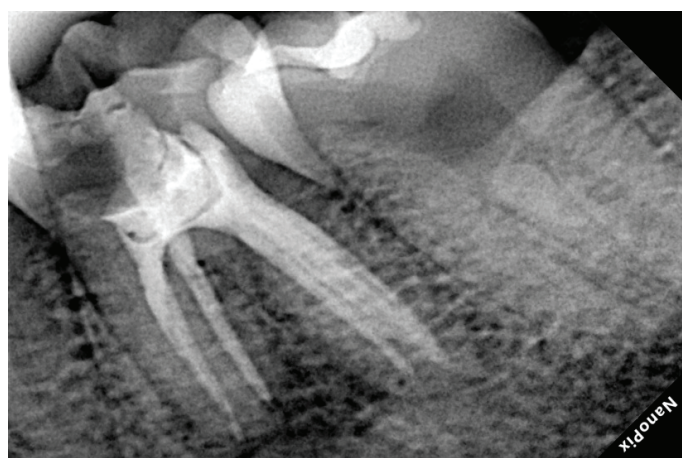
Angulated preoperative radiograph of the molar
